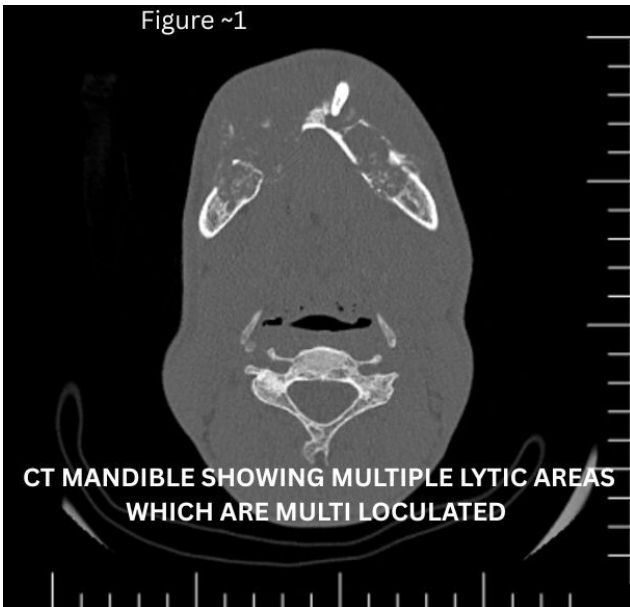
Axial CT image (bone window) showing multiloculated expansile lytic lesions involving the parasymphiseal region and bilateral mandibular bodies with marked cortical thinning and a focal cortical breach
